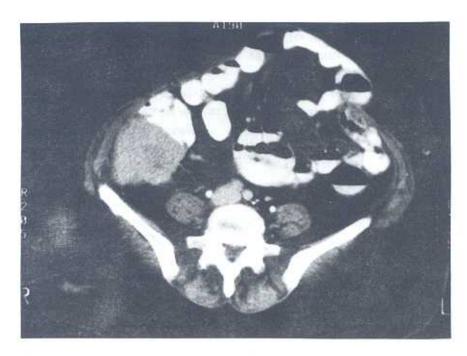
Postoperative recurrent ovarian carcinoma. In sequential CT scans (a,b), there is periceacal peritoneal mass and mesenteric heterogenity
